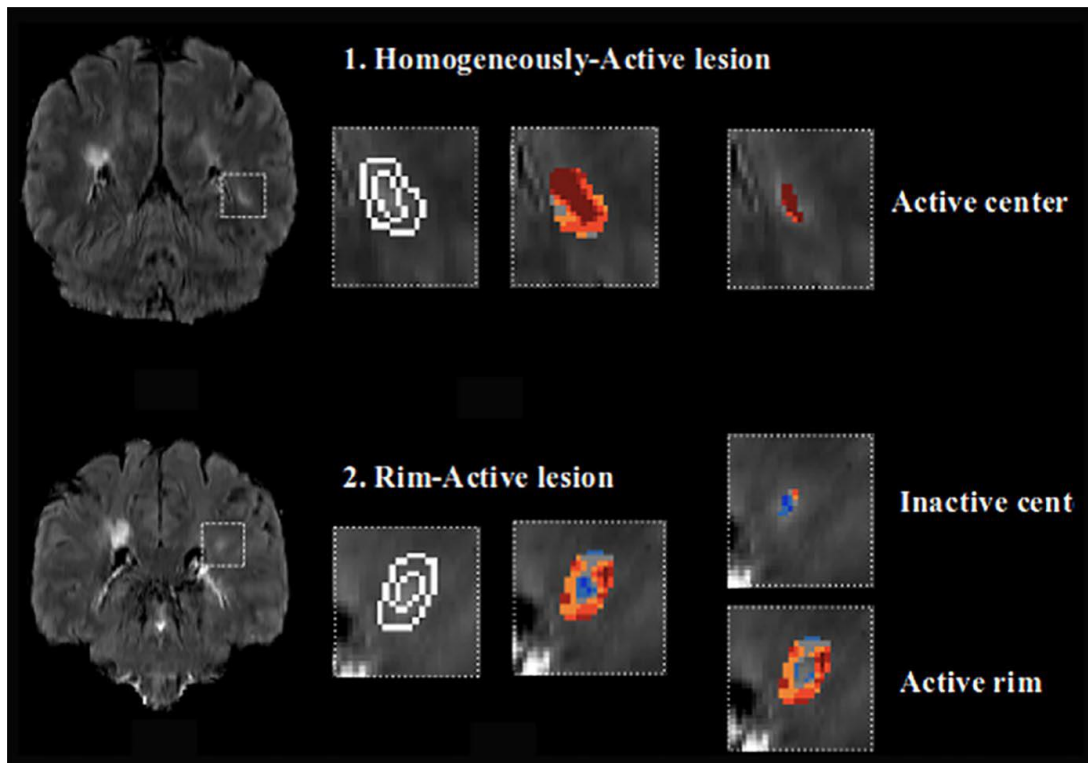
CALs can be identified using Positron emission tomography (PET) -imaging with translocator protein (TSPO) radioligands, where TSPO-PET signal reflects activated microglia and macrophage density. White boxes on the coronal FLAIR MRI slices indicate WMLs of interest. Hot colors denote increased inflammatory activity within CALs, distinguishing homogeneously active lesions with active centers from rim-active lesions, or PRLs, with inactive center and active rims.¹⁷
